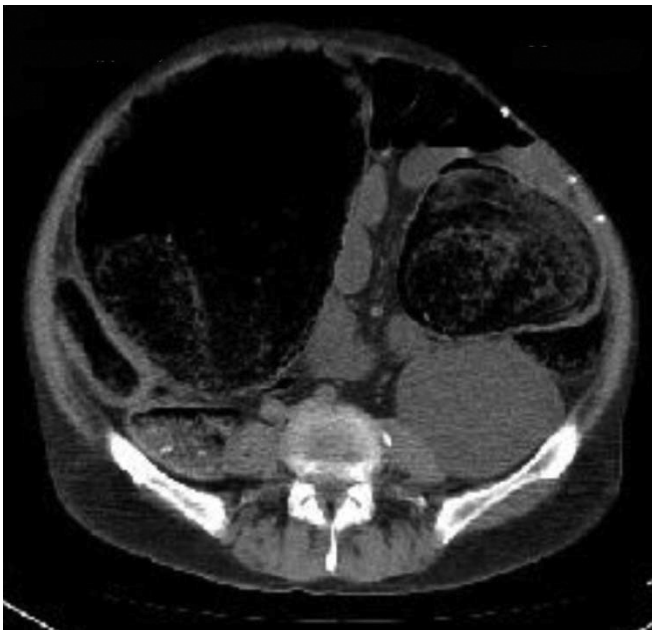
An axial CT section showing well-formed, large faecal ball in dilated sigmoid colon
